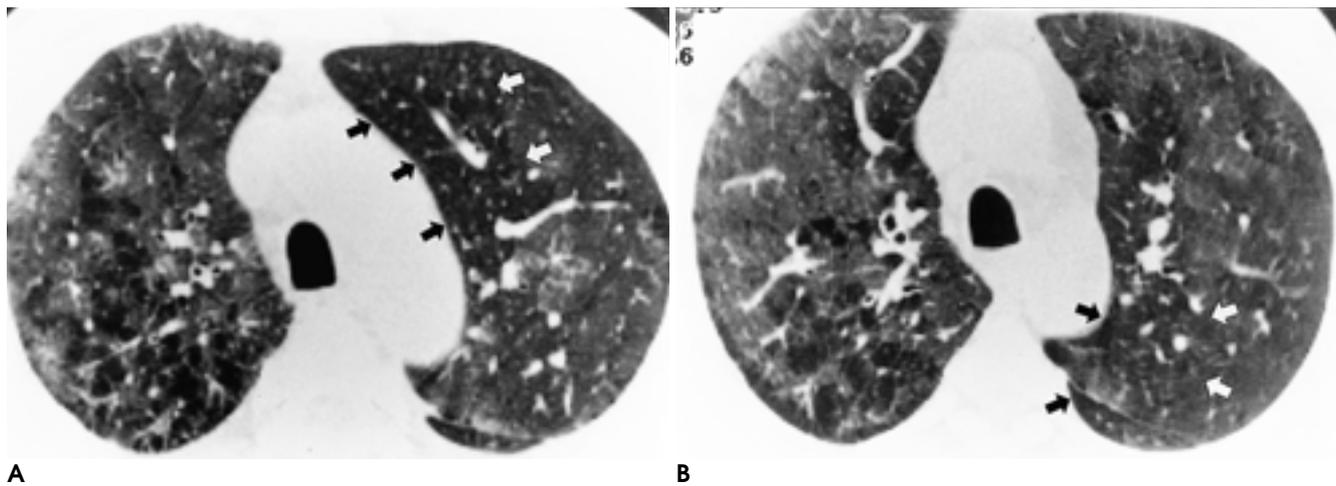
A 54-year-old man with leptospirosis. Thin-section CT shows widespread patchy ground glass opacity.
